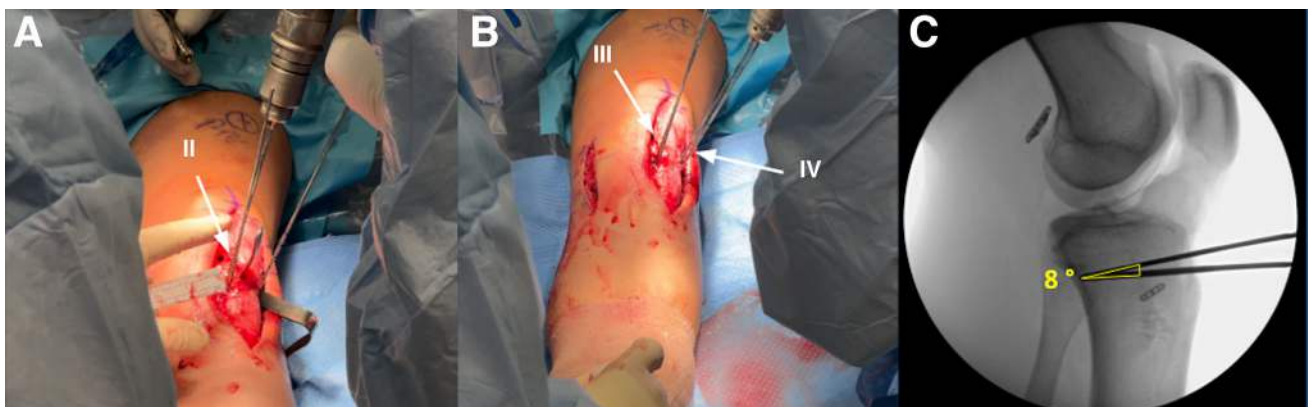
Left knee proximal pin placement progression for the slope-reducing anterior closing wedge osteotomy with the patient in a supine position. The correction is measured on the anterior cortex with 1 mm of correction equated to a 1° reduction. Pin trajectory is approximated, and 2 pins (III, IV) are placed 8 mm superiorly from the distal pins on the anterior cortex, meeting the previous pins at the posterior cortex to achieve a wedge (A and B). Intraoperative fluoroscopy (C) is used to obtain lateral radiographs to confirm the pin placement, and the desired wedge correction angle is established.
